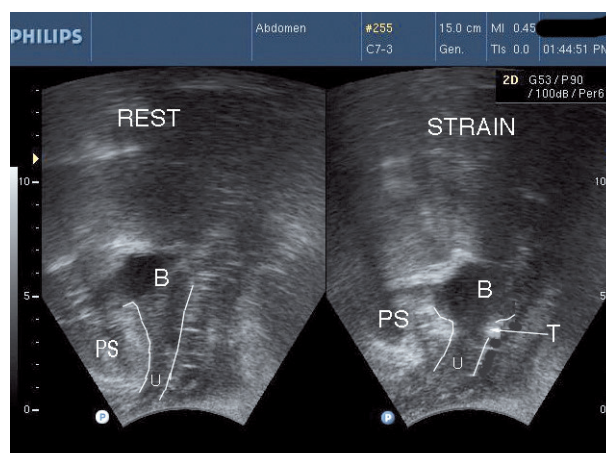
Transperineal ultrasound showing opening out of the posterior urethral wall during straining. PS=pubic symphysis; B=bladder; U=urethra; T=tape.
